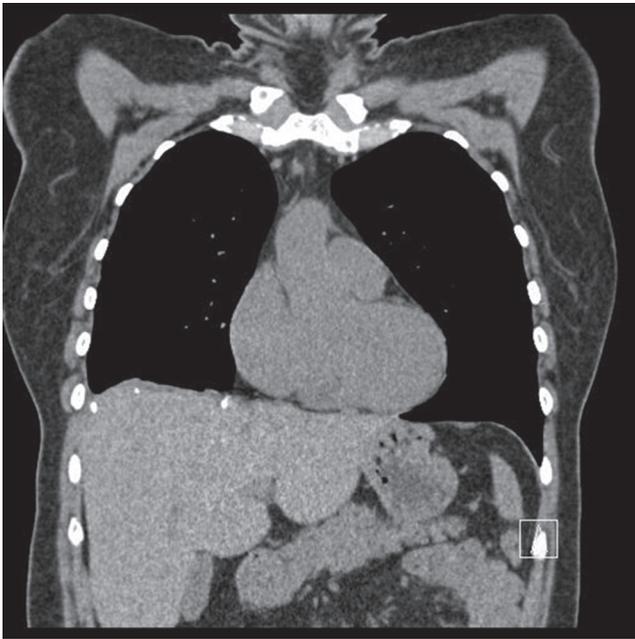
Postoperative Thoraco-Abdominal CT Scan. Coronal section. Thoraco-Abdominal CT-scan showing no recurrence and diaphragmatic spontaneous hyperdensities as metallic staples.
